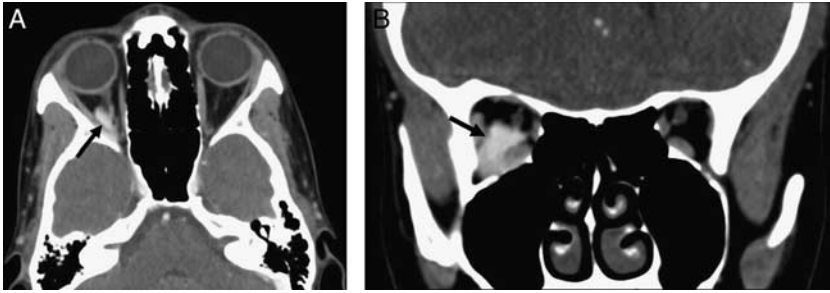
34-year-old woman presented with positional right periorbital pain. Patient was imaged during a Valsalva maneuver. Axial (A) and coronal (B) images of a contrast-enhanced computed tomography through the level of the orbits demonstrates an enhancing tubular structure in the right orbital apex consistent with a varix (black arrows).
